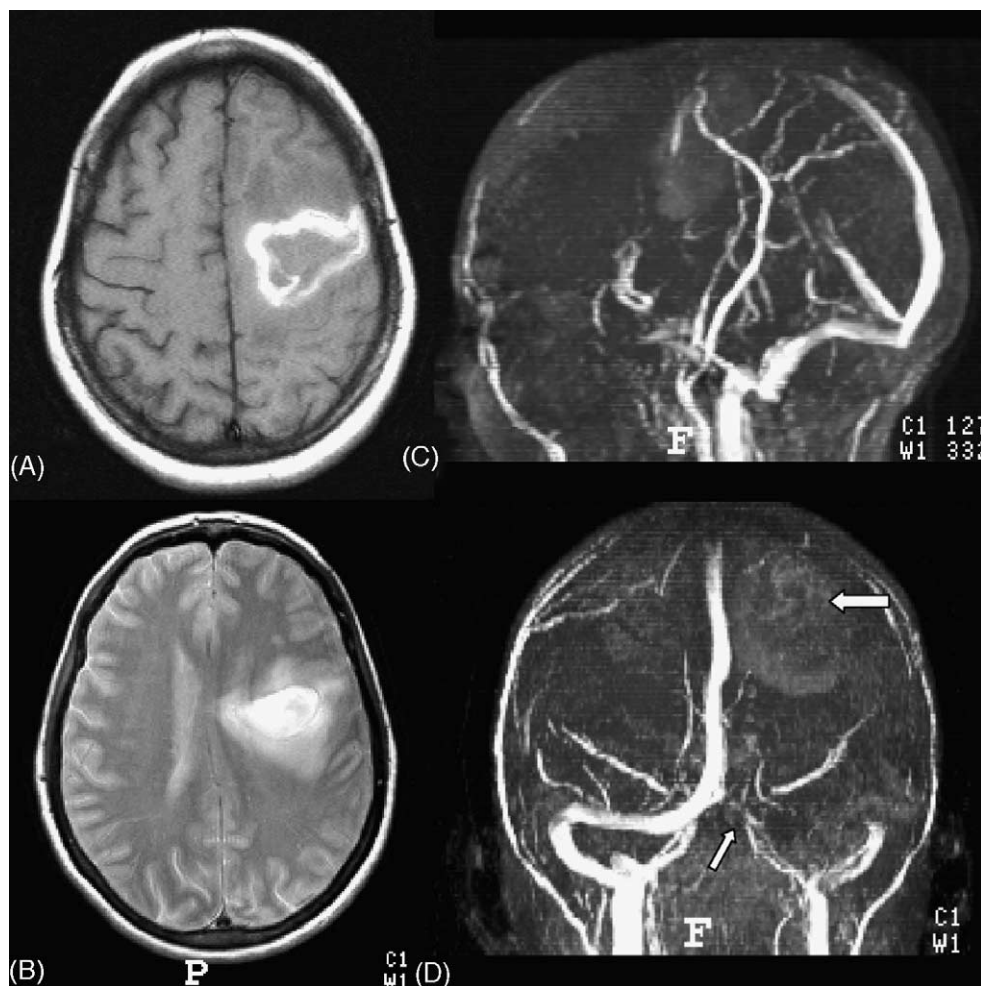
MRI of patient (#6) with CVT secondary to the G20210A mutation in the prothrombin gene showing axial T1-weighted image (A) and proton density image (B) showing intraparenchymal hemorrhage and perilesional edema in the convexity of the left frontal region secondary to CVT. MRV (C, D) showing a signal dropout of blood flow in the left transverse sinus (small arrow) (D) with hyperintensity (large arrow) corresponding to the area of hemorrhagic infarct. There is also signal dropout in the superior sagittal sinus.
